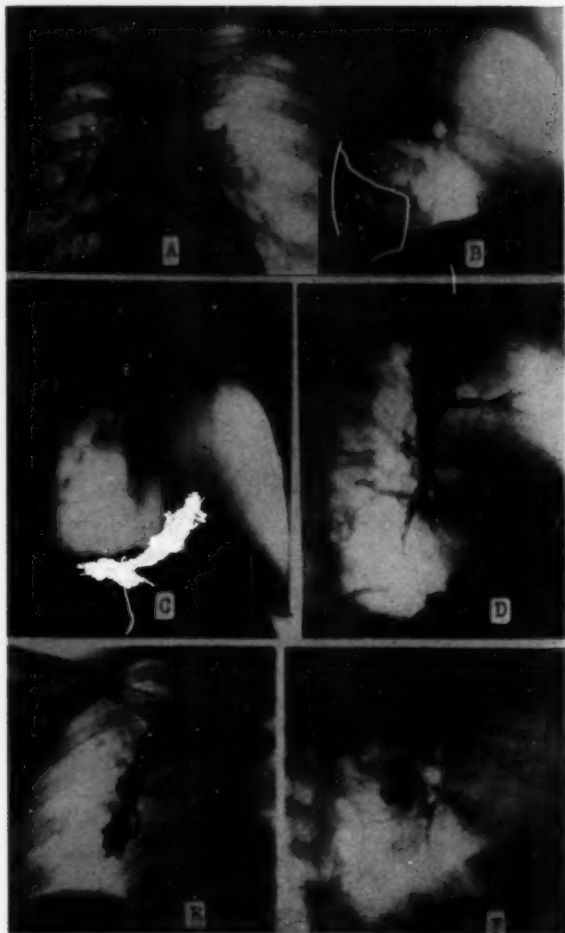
Case 4: No cavity could be demonstrated with AP and lateral roentgenograms and lateral planigram (A, B and C). Lateral bronchogram of the right lung (D) shows "dead tree effect" in the superior segment of the right lower lobe.
